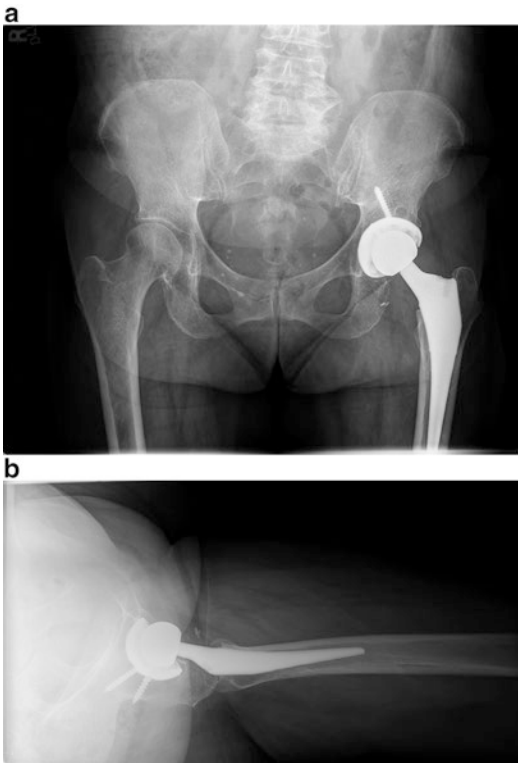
AP (a) and lateral (b) radiographs of an infected THA upon presentation to our institution. The patient presented with a 6-month history of increasing groin pain and grew MRSA after hip arthrocentesis
